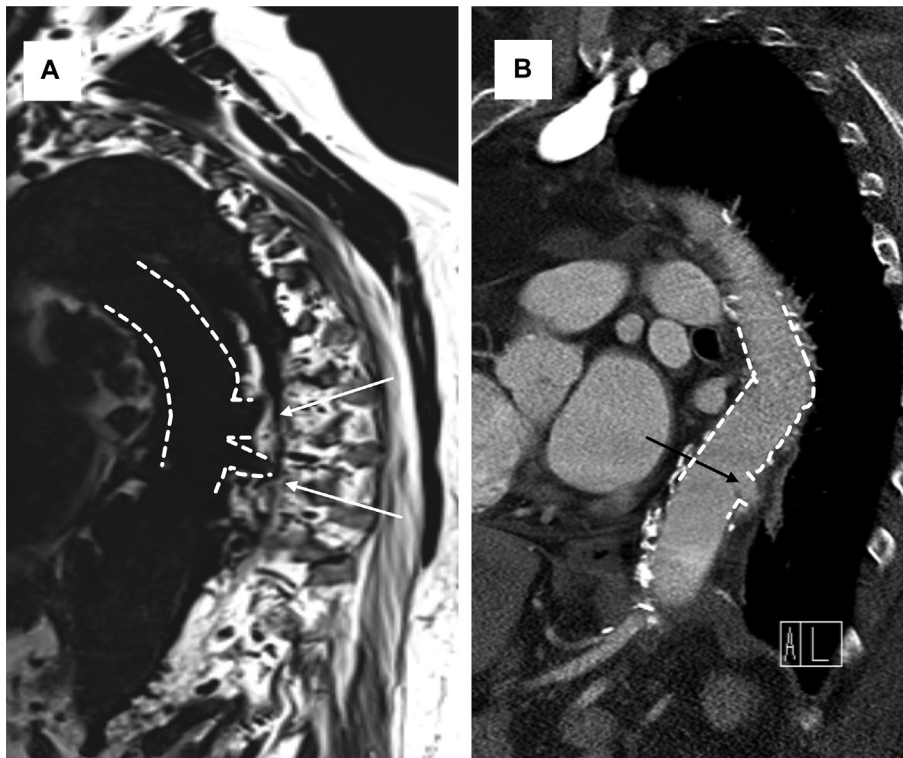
A, Postoperative magnetic resonance imaging of the spine. The patent intercostal artery bypasses are indicated. B, Postoperative computed tomography (CT) scan 12 months after surgery. The occluded intercostal artery bypass is indicated.
